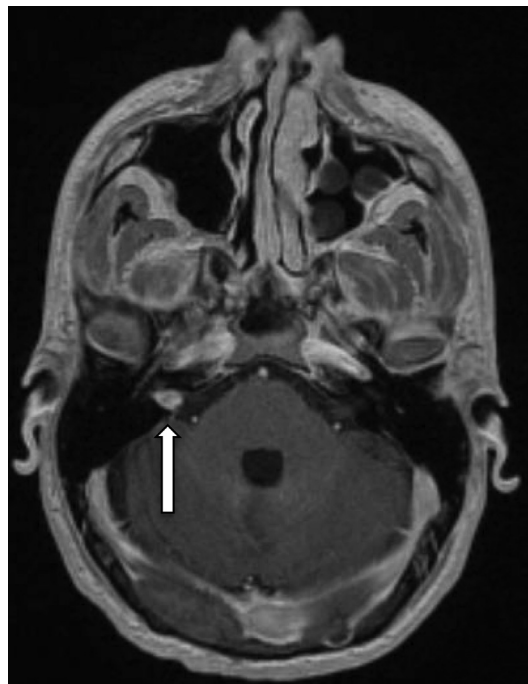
Axial T1 contrast MRI showing a 9-mm endolymphatic sac tumor in the right internal auditory canal (arrow) in a patient with VHL disease.
